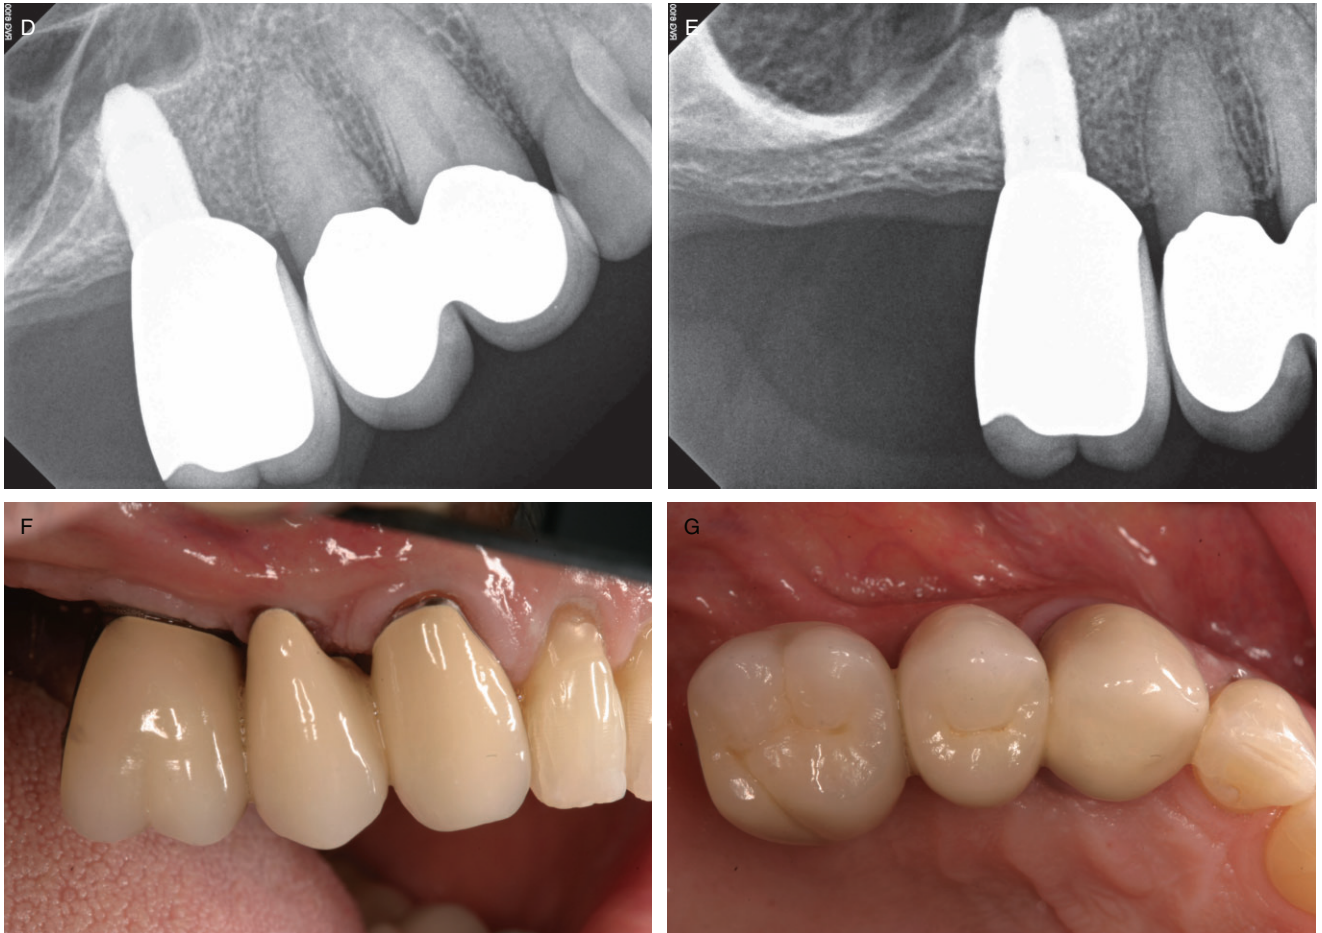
(continued) *D* and *E*, Periapical radiographs taken at 3 and 4 years postloading. Note crestal bone stability and apical shifting of maxillary sinus floor as a result of sinus grafting. *F* and *G*, Buccal and occlusal view of the final restoration in place at 4 years.
